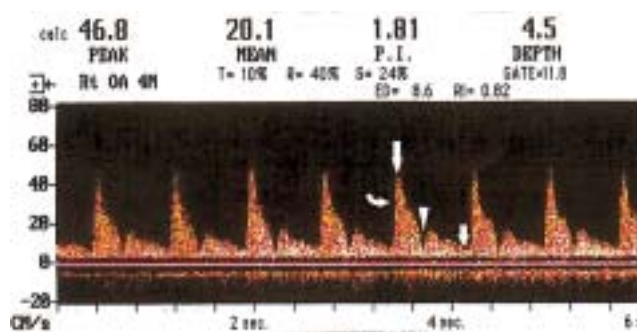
Color Doppler waveform of the ophthalmic artery showing initial steep systolic velocity rise (curved arrow), and notched "incisure" in midsystolic flow (arrowhead). Only such waves were selected to measure the blood flow velocity parameters. The highest value of the wave is the peak systolic blood flow velocity (long straight arrow) and the lowest value of the wave is the end diastolic blood flow velocity (short straight arrow).
